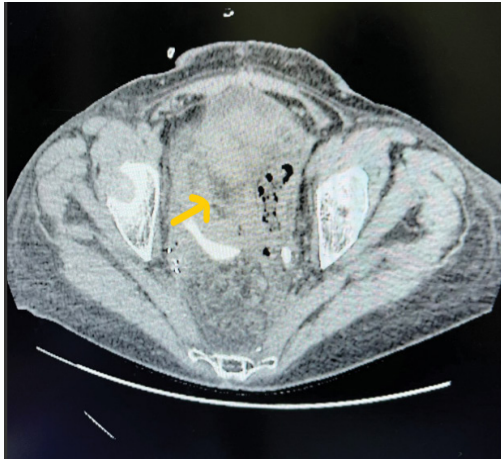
CT aspect of the invading tumour.
